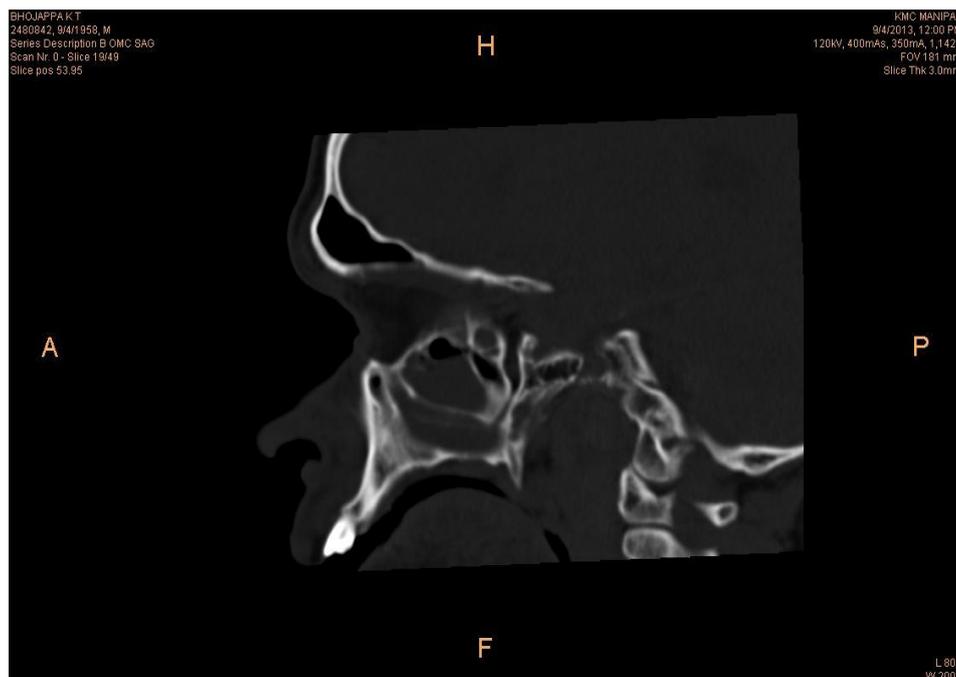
CT scan, Sagittal section- Intranasal extension of the lesion extending posteriorly through choana into the nasopharynx
